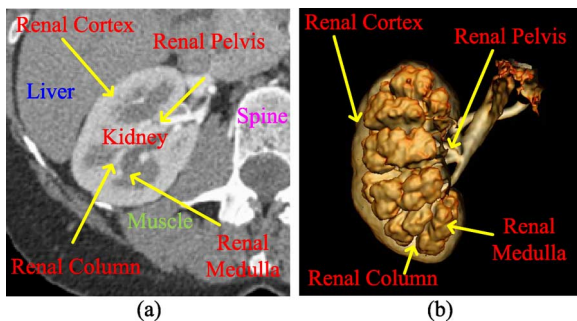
Anatomical structures of kidney. (a) CT image of the kidney. (b) Kidney iso-surface rendering.
